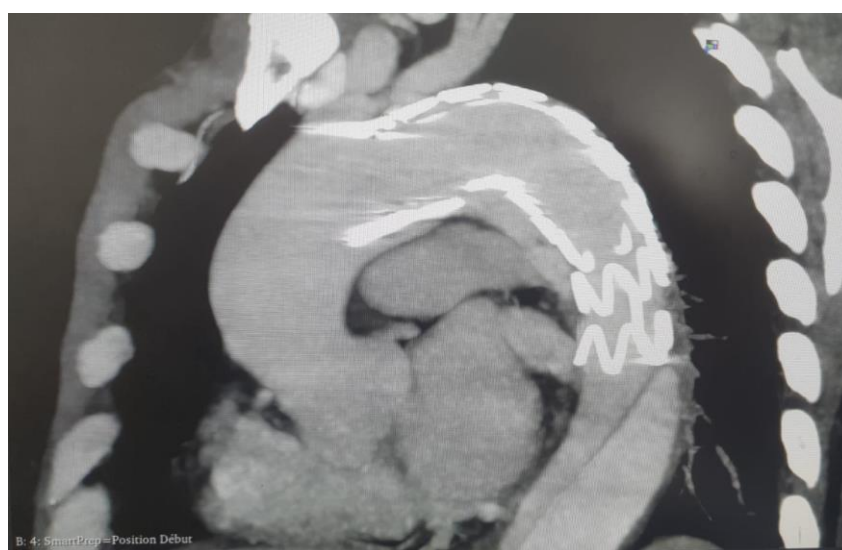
Post-TEVAR CTA demonstrating a proximal type IA endoleak at the lesser curvature (“bird-beak” configuration), with persistent opacification of the aneurysmal sac, consistent with continued false lumen perfusion
